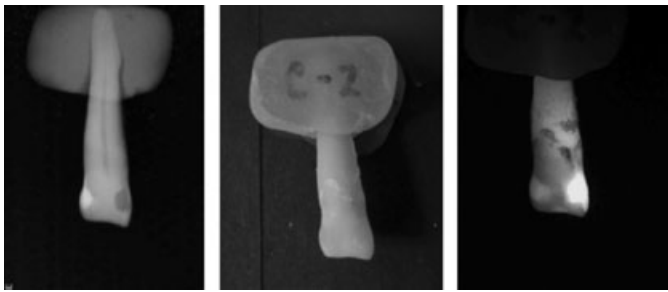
Radiograph of extracted tooth restored with two brands of resin, left. Center, tooth illuminated with white light. Right, tooth illuminated with a 14 LED 380 nm UV flashlight.
